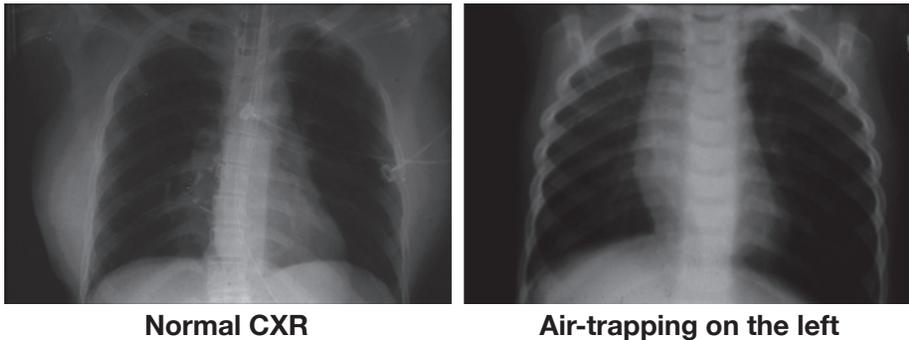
Chest x-ray showing airtrapping.
